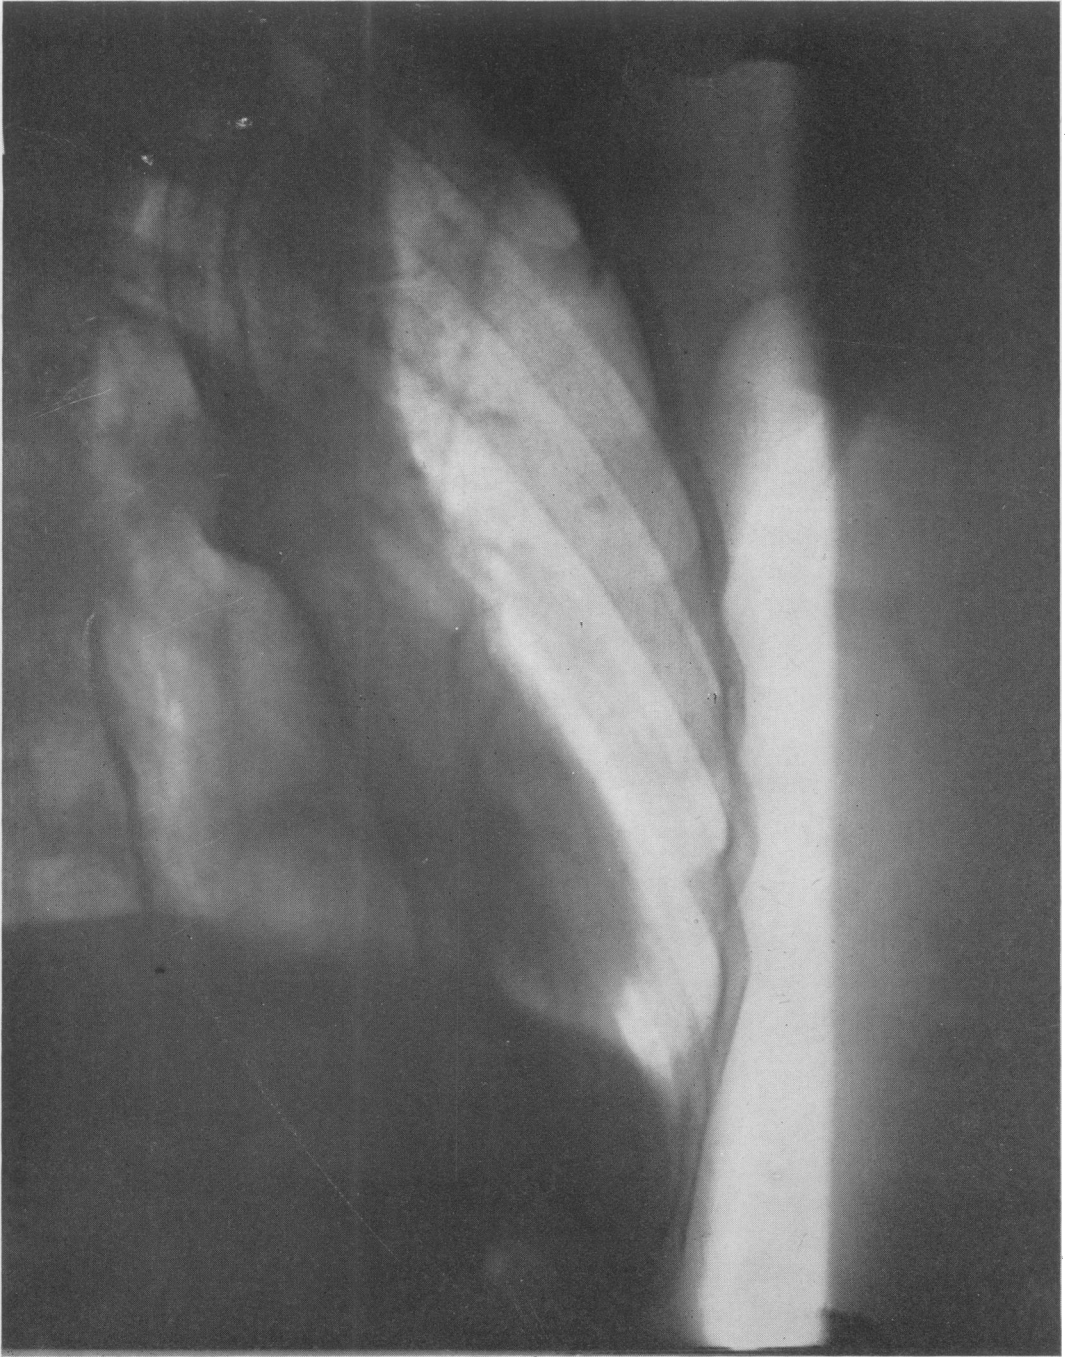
Post-operative radiograph, showing how stomach is fixed up behind the oesophagus, making stoma on the anterior wall.
